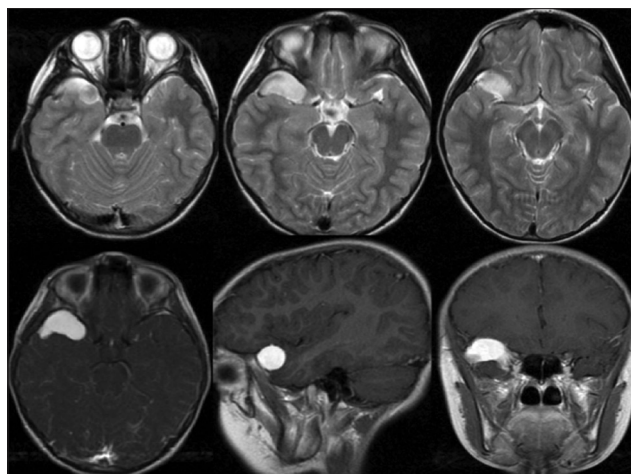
Cerebral magnetic resonance image. Top row: Axial T2-weighted images. Bottom row: Axial, sagittal, and coronal T1-weighted images with intravenous contrast. A well-defined elongated extra-axial lesion located anterior within the right middle cranial fossa, with slightly heterogeneous high signal intensity on T2-weighted images, and high homogeneous contrast enhancement
